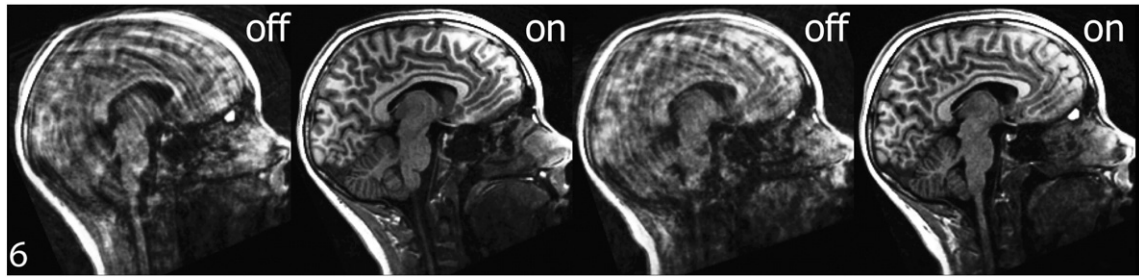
T1-weighted midsagittal images by PROMO status for one subject. Reconstructed images for subject number six, comparing 3D IR-SPGR scans with PROMO off versus on, show greater image clarity and reduced blurring, ringing, and ghosting for both acquisitions using PROMO correction.
